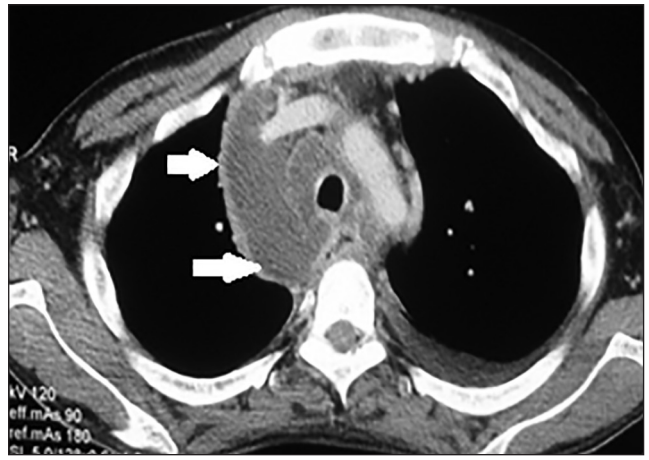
CT chest: Large collection in the mediastinum compressing the trachea. Left pleural effusion can also be seen
